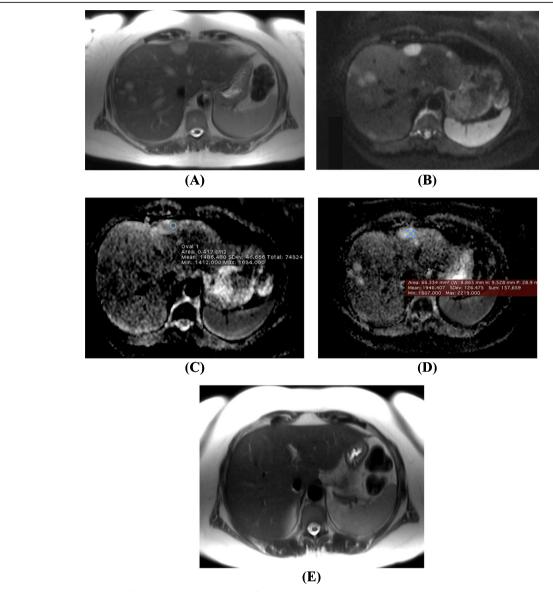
Case (1): A 48 year old female patient with history of rectal adeno-carcinoma with hepatic metastasis, patient has contrast sensitivity and only non-contrast MRI was done. a) Base line pre chemotherapy axial T2 MRI revealed; multiple lesions, the target lesion is a well-defined sub capsular hyper intense lesion measuring about 2.5cm seen in segment III. b) Corresponding axial baseline diffusion weighted image of the previous T2 target lesion with b Value of (800 m2/sec) shows the lesion displaying hyper intense signal. c) pre therapeutic ADC image revealed diffusion restriction and ADC value of 1.49 x10-3 m2/sec (d) post therapeutic (21 days after chemotherapy) ADC map showing increase in the ADC value up to 1.96 x10-3 m2/sec (e) 2 month follow up non contrast T2 MRI revealed total resolution of the previously noted target lesion denoting complete response according to RECIST criteria
